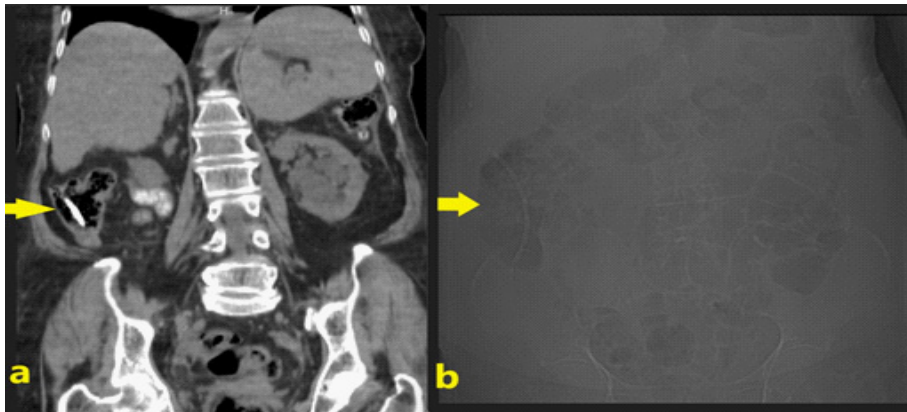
CT (a) and plain radiography (b) revealing a biliary stent in the ascending colon.
